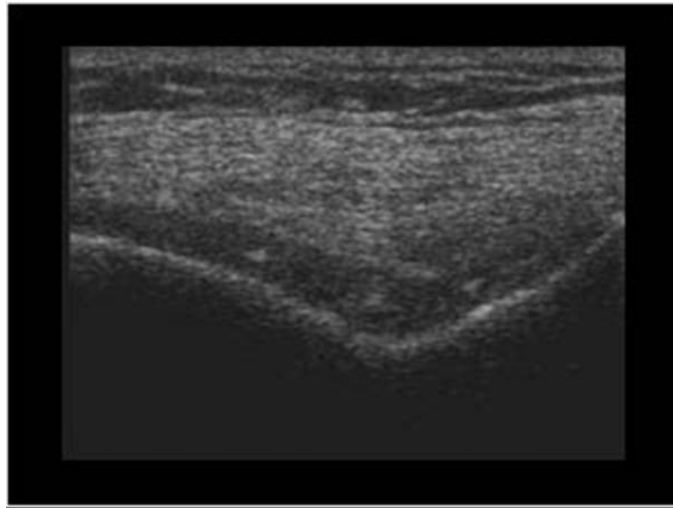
Knee joint Cartilage calcifications Ultrasound
